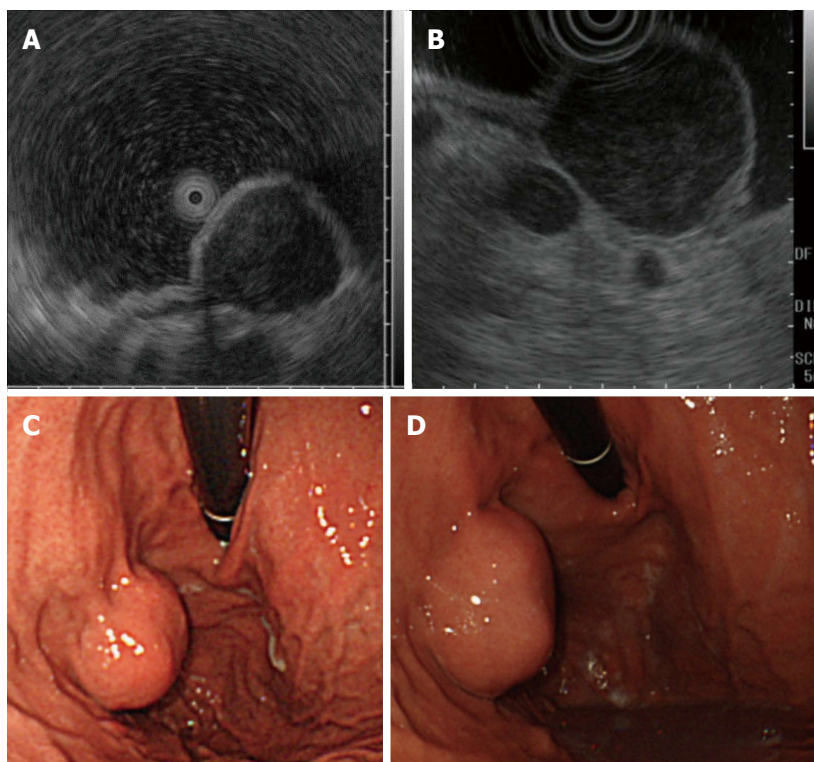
Gastrointestinal submucosal tumors low grade: Doubling time is 17.2 mo. A: EUS finding at baseline, tumor diameter is 22.0 mm; B: EUS finding at four years later, tumor diameter is 34.0 mm; C: Endoscopic finding at baseline; D: Endoscopic finding at four years later. There is almost no change in endoscopic findings in four years. EUS: Endoscopic ultrasound.
